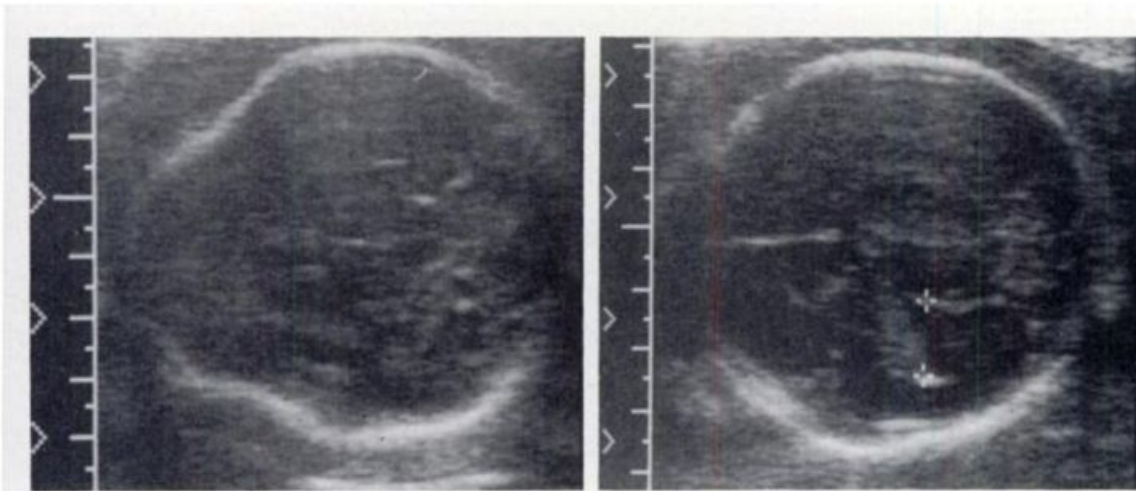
Spina bifida missed at sonography. Transverse cranial sonogram at 21 weeks demonstrates moderate dilatation (straight arrows) of the ventricles (V) that was initially noted on a sonogram obtained elsewhere. A spinal defect was not detected at sonography but was found at autopsy after termination of pregnancy. On retrospective evaluation, a concave frontal contour is identified (curved arrow).
